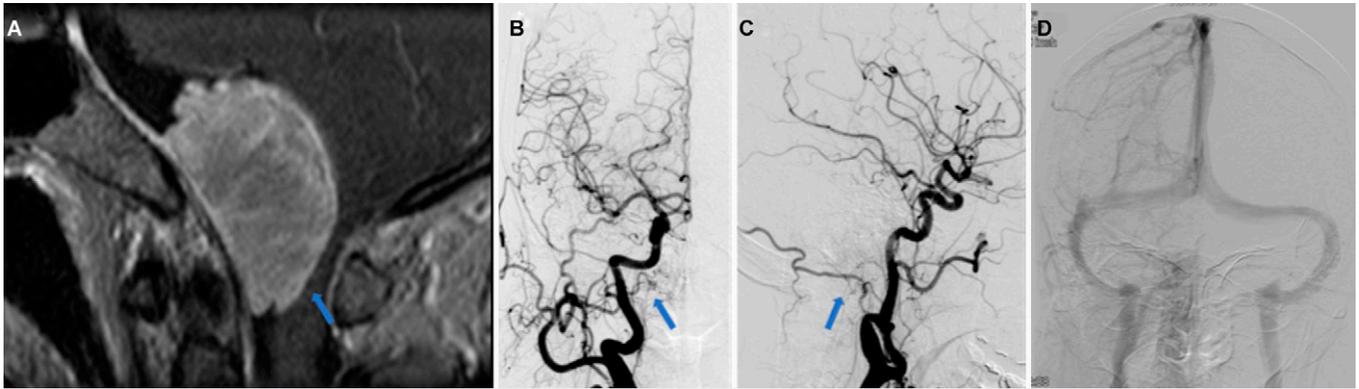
Preoperative imaging. A: Sagittal gadolinium-enhanced MRI before tumor resection. An extraaxial tumor with enhancement on the foramen magnum was detected (*blue arrow*). B: Anteroposterior view of digital subtraction angiography of the right common carotid artery before surgery. The right APA (*blue arrow*) was feeding the tumor. C: Lateral view of digital subtraction angiography of the right common carotid artery before surgery. The right OA (*blue arrow*) was feeding the tumor. D: Anteroposterior view of digital subtraction angiography of the right common carotid artery before surgery. No obvious vascular malformations or stenosis of the sigmoid sinus was detected.
